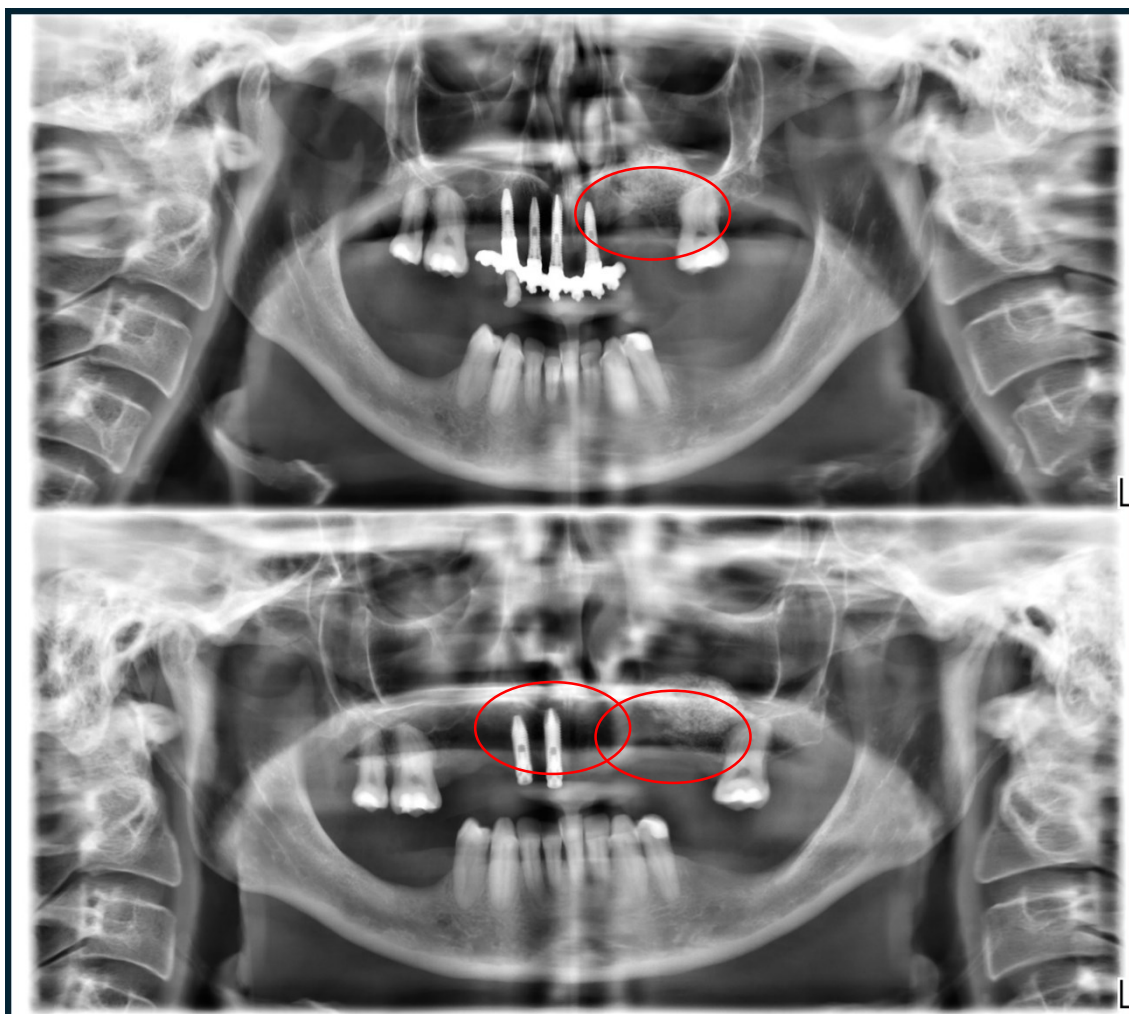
Patient SP2, orthopantomography comparison time 1 28/10/2023 (above), time 2 03/07/2024 (below)
